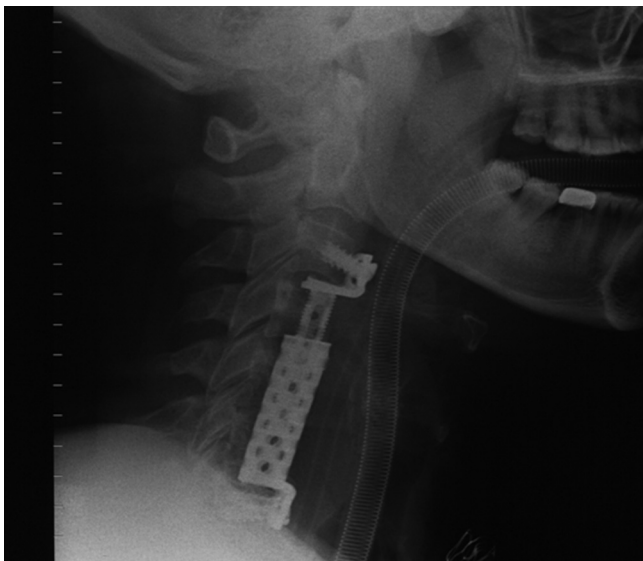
The excellent intraoperative X-ray control during the second operation consisting of C4 somatectomy, telescopic extension of the construct up to C3.
